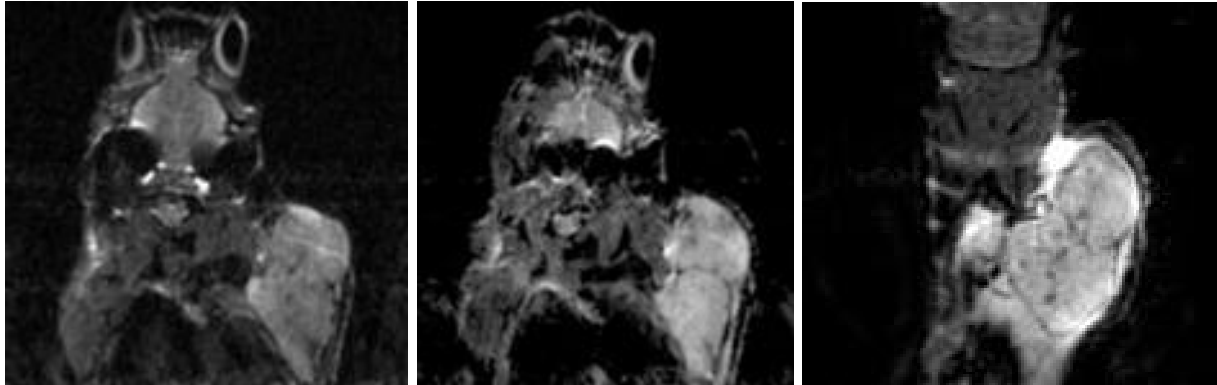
Multi-slice multi-echo (MSME) MR images of a treated tumor pre-PDT (left), immediately post-PDT (middle), and 24 hours after PDT (right). The signal intensity values changed 24 hours after the treatment.
